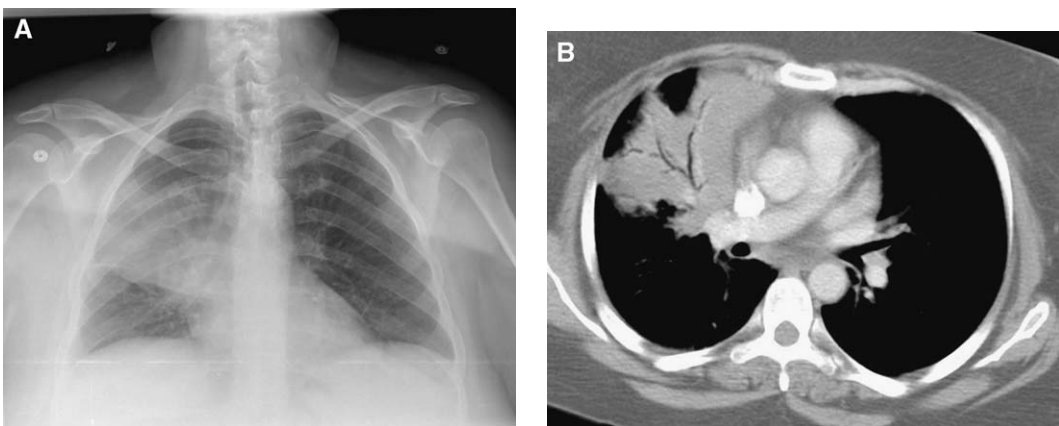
Right upper lobe pneumonia caused by *S pneumoniae*. Posteroanterior (PA) chest (A) and CT scan (B) soft windows demonstrating air bronchogram.
